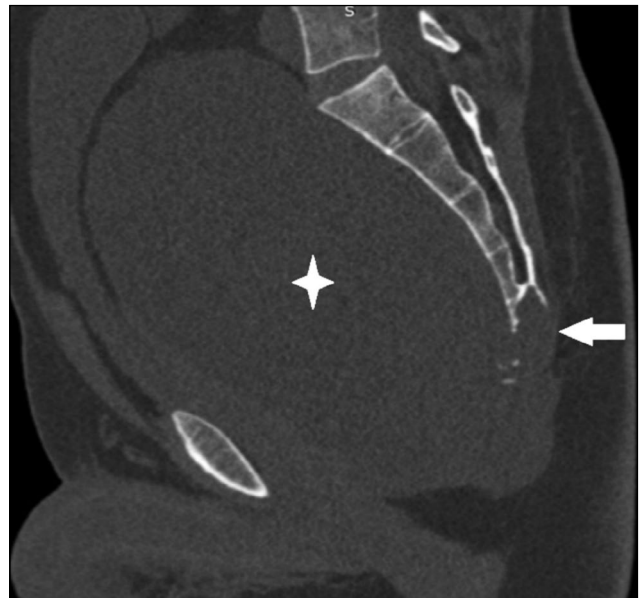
CT in the sagittal plane, there is a lytic focus of destruction of the C4, C5 and coccygeal vertebrae (arrow), a massive soft tissue component in the pelvic cavity, reaching the level of the L5 vertebra (asterisk).
